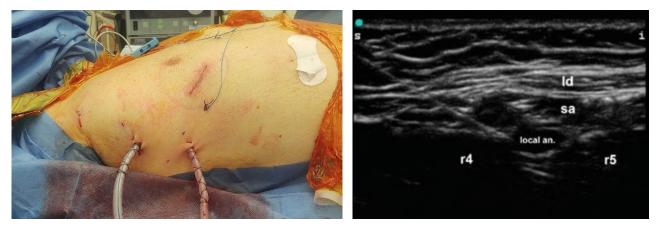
Patient positioning on the end of the surgery (left), ultrasound image (right). Ultrasound image from NYSORA.com : needle insertion in-plane and local anesthetic spread : Ld (Latissimus dorsi), sa (serratus anterior muscles), r4 (rib 4), r5 (rib 5)¹¹.
